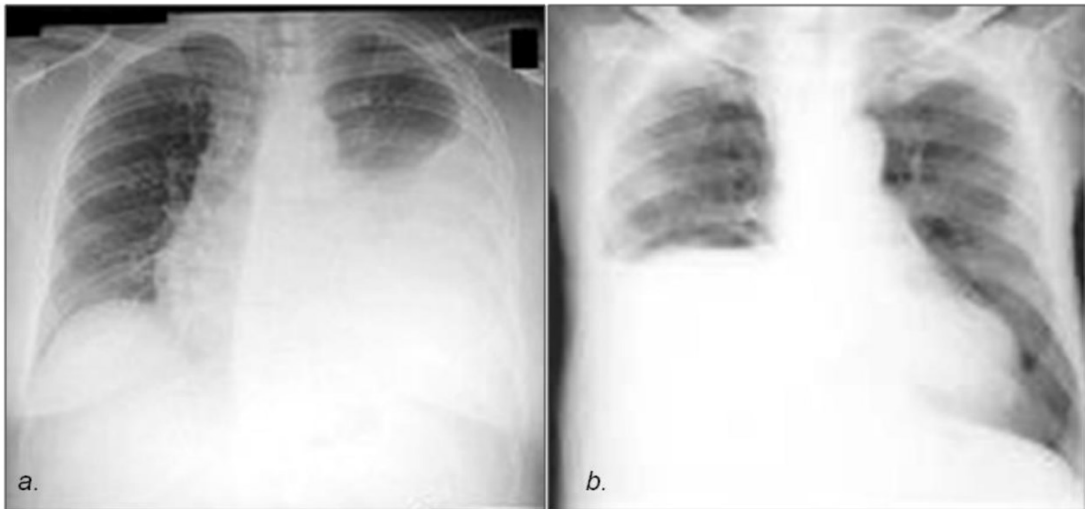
Chest radiographs in P-A projection of the chest with left (a) and right (b) pleural effusion, respectively.
